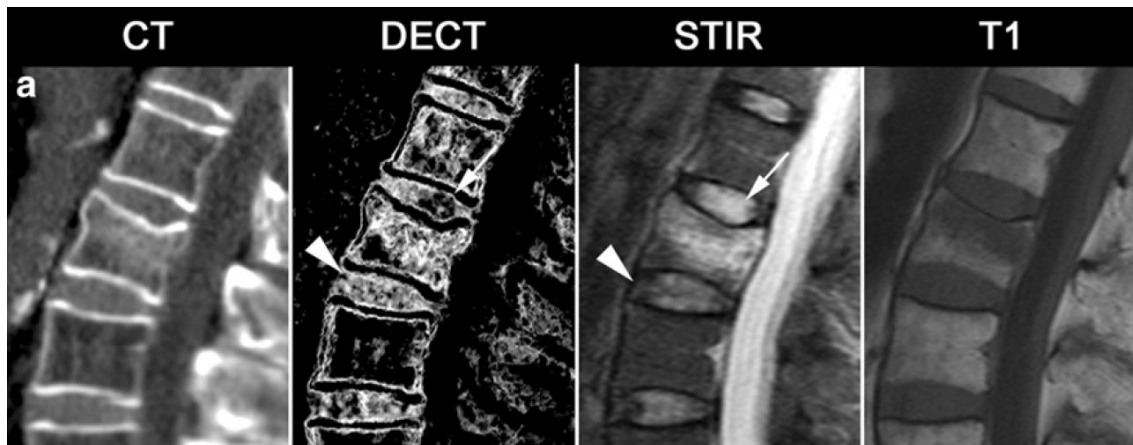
Patient with a compression fracture with bone marrow edema at L2 and an increased signal intensity in the disc L1/2 based on MRI-STIR. Image from publication by Pumberger M et al [123]
